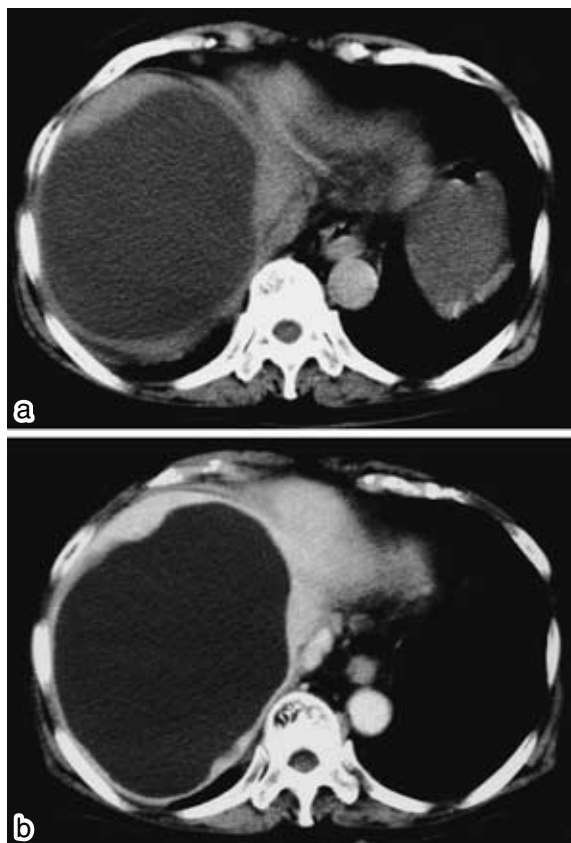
Computed tomography (CT) on admission reveals a 15 cm hepatic cyst in the anterior-superior segment of the liver (a). The wall of the cyst is thickened and enhances with contrast media (b).
